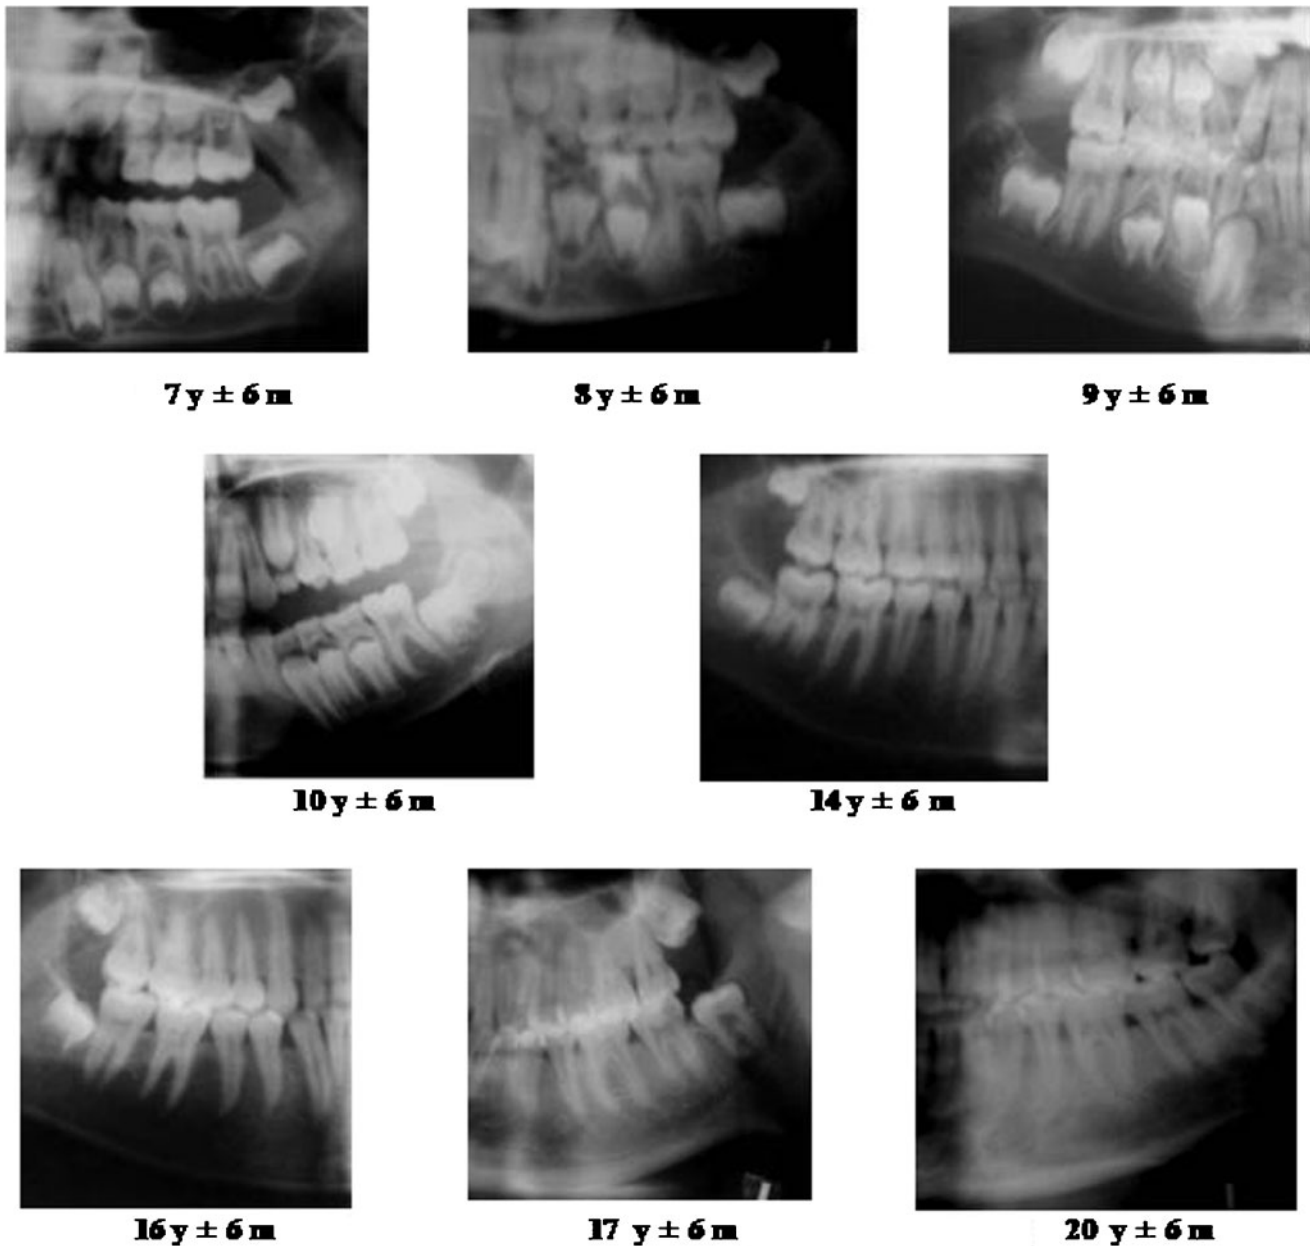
Cropped radiographic images showing dentition in various stages of development corresponding to given age of person (y = years, m = months)
